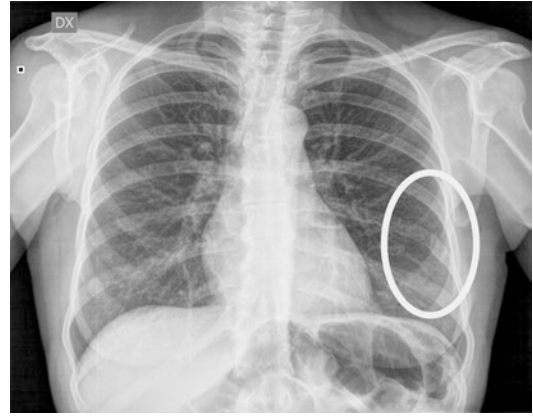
Plain radiograph: outcome of previous left eighth rib fracture (white circle)
